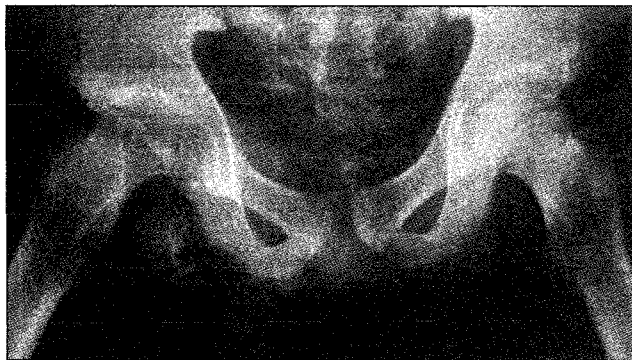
Antero-posterior radiograph of the pelvis showing transepiphyseal separation with the capital epiphysis dislocated inferiorly.
